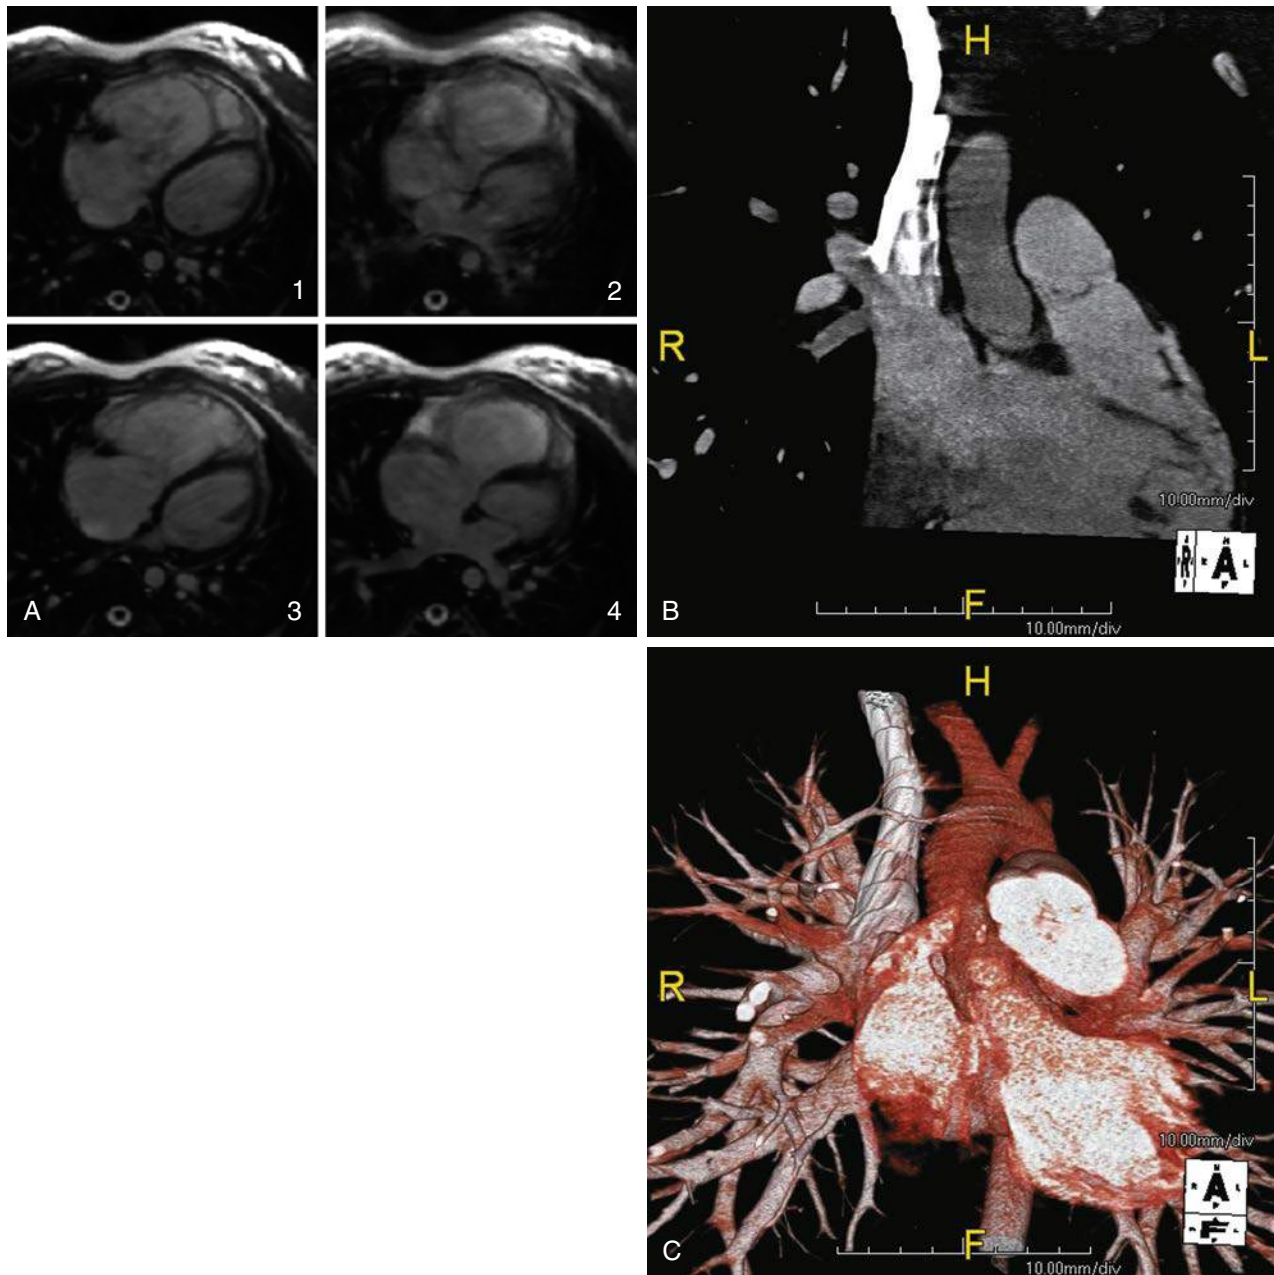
A, Cardiac magnetic resonance imaging four-chamber view shows right ventricular enlargement from a superior-type sinus venosus atrial septal defect. The enlarged right ventricle is best seen in panels 1 to 3, whereas the communication along with some of the pulmonary veins is best seen in panel 4. B, Maximum-intensity projection multiplanar view of a computed tomography (CT) angiogram also shows partial anomalous pulmonary venous connections of the right upper and right middle lobe pulmonary vein (RMPV) to the right atrium. The superior vena cava (SVC) is filled with contrast agent, and there is some filling artifact within it. C, A color-enhanced 3D reconstruction of the same CT angiogram is shown. Here the right upper and RMPV can be seen even more clearly draining into the SVC.
